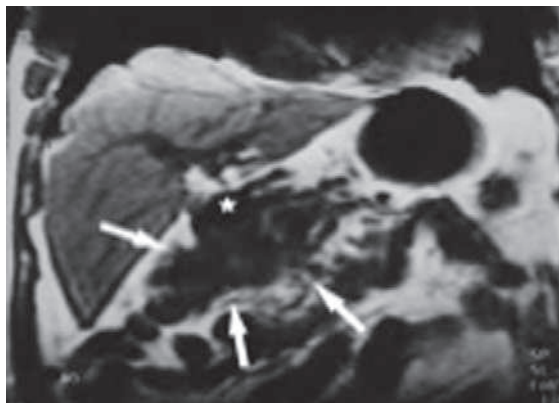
T4 Gastric Carcinoma. 54-year-old woman. Coronal T1-weighted MR image shows matted appearance of gastric tumor, duodenal loop, and omentum of hepatic flexure of colon (MRT4) (*arrows*). These structures adhered to each other and were infiltrated by tumor, as noted at surgery (pT4). Star indicates pyloric antrum of stomach (Sohn, et al. 2000).
